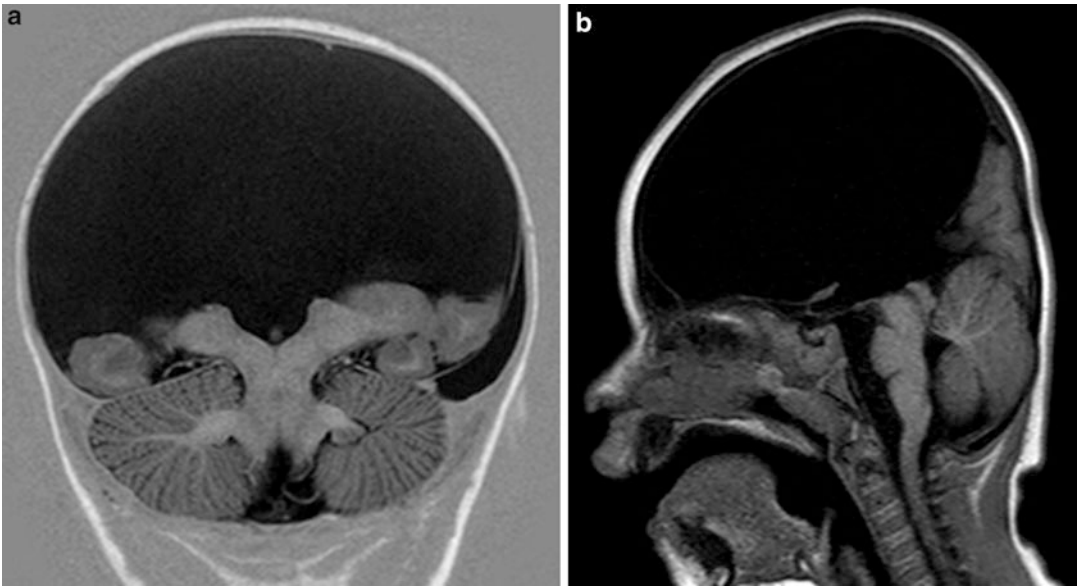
(a, b) These two MRI images of the brain was from 1-year-old girl with seizures. Coronal image shows complete absence of the cerebral hemispheres with the exception of some portions of the inferior temporal lobes. The cerebellum is normal (a). The sagittal image shows
